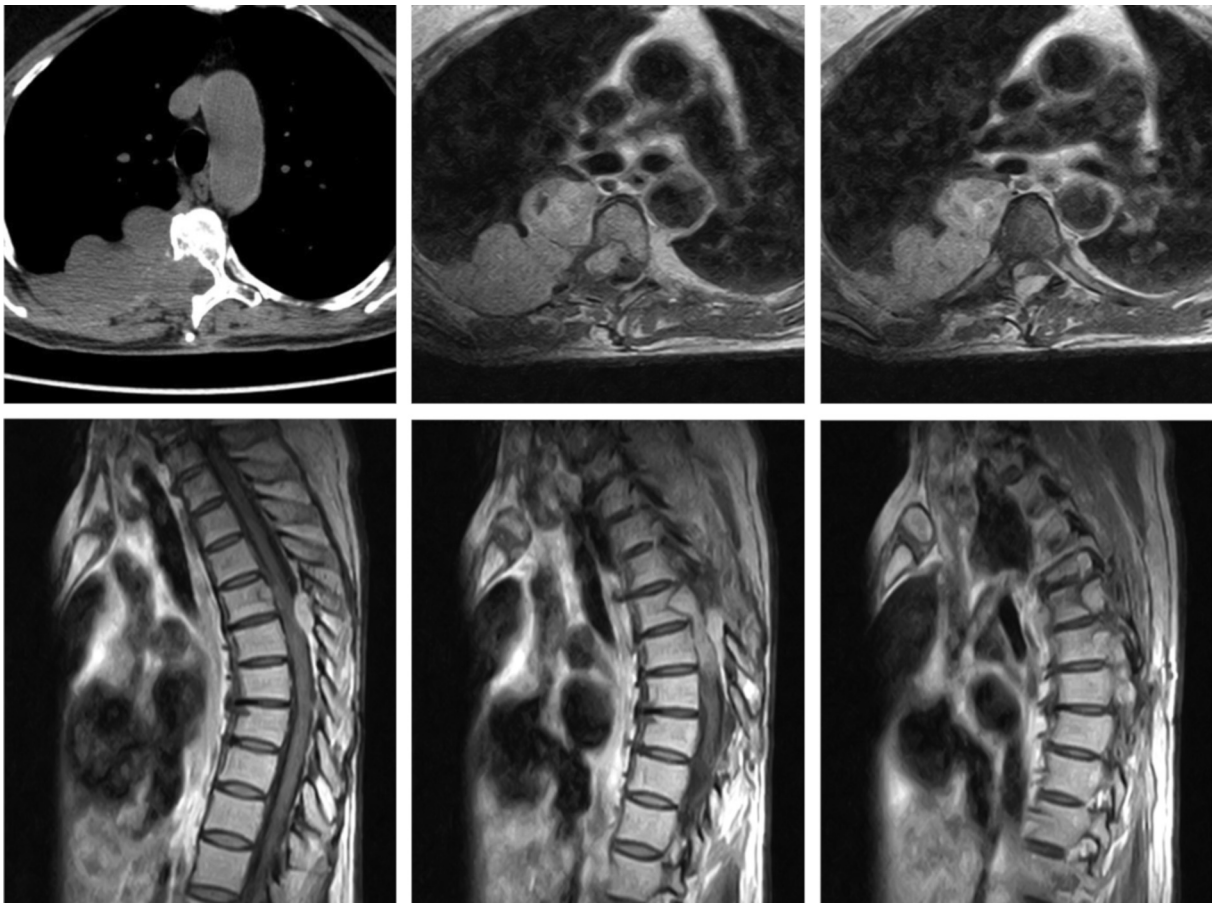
Pre-operative MRI and CT scan.
